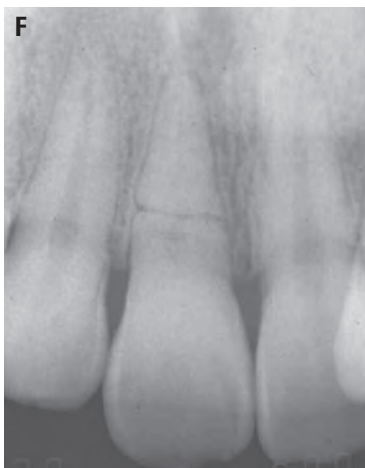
Continued. D, Radiograph taken immediately after the reduction of the fracture and splinting. E, Photograph taken after removal of the splint. F, Radiograph taken 2 years post-trauma. Note the healing by calcification within the root canal space. No root canal treatment was necessary.
